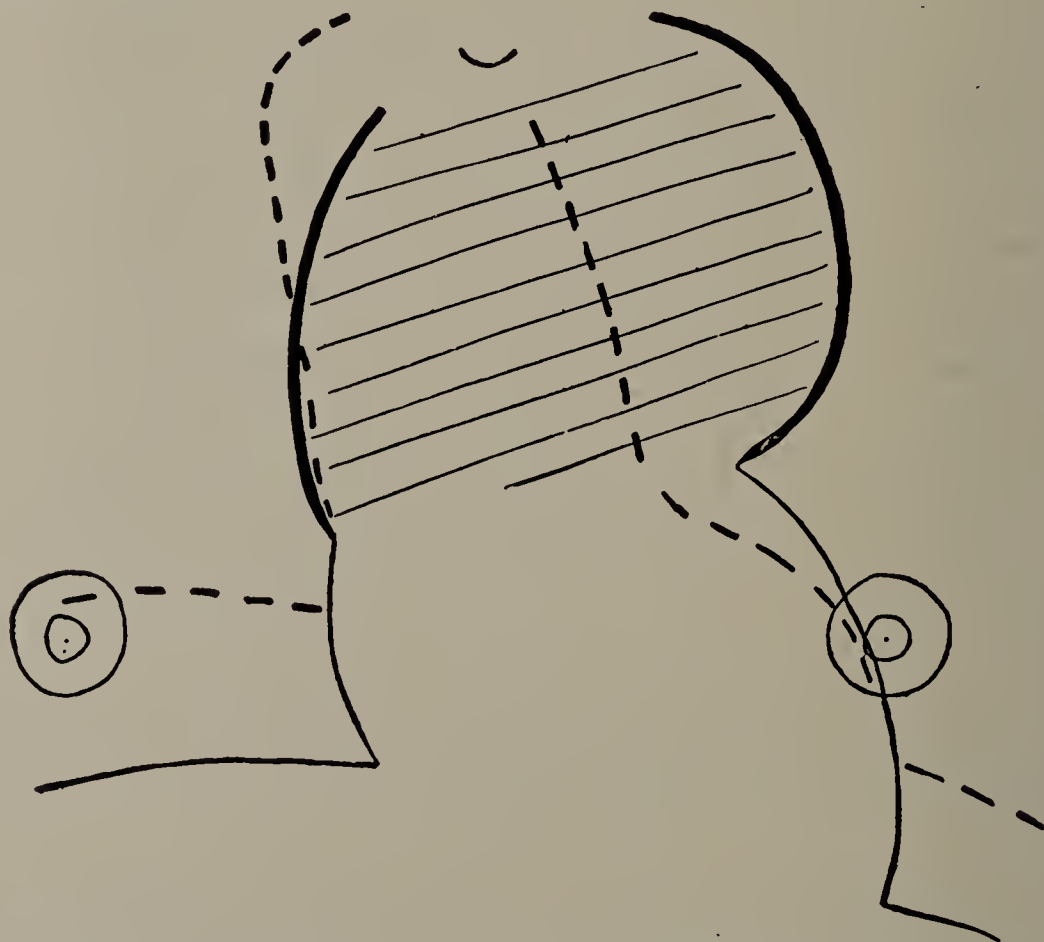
Case VI. Aneurism of aorta in James L., thirty-three years old. Broken line shows outline of aneurism by percussion. Full line shows X-ray outline of aneurism and heart. The part of the aneurism to the left of the sternum was not indicated by percussion. The horizontal line near the nipples shows position of diaphragm in expiration (broken line) and in full inspiration (full line) by X-ray examination. (Cut one-third life size.)
